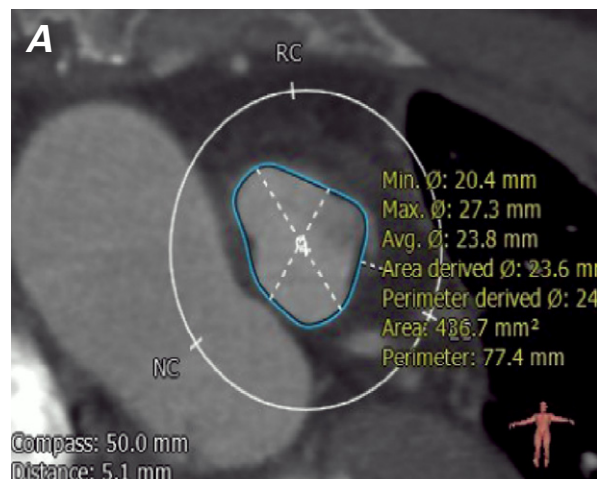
Computed tomographic angiograms show the sizing of the pulmonary valve, with pulmonary artery diameters at A) 5 and B) 10 mm, and right ventricular outflow tract diameters at C) 5 and D) 10 mm.
